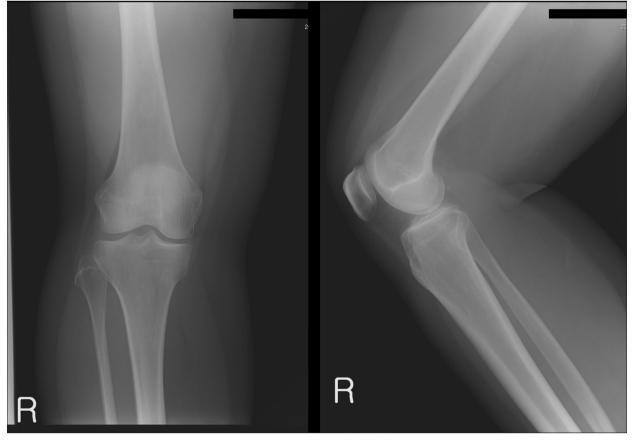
Plain radiographs of the knee joint at the first visit showed no abnormalities caused by the soft tissue tumor or osteoarthritis.
